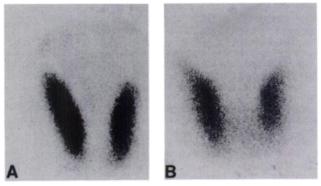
Normal thyroid gland scintigram. Little or no evidence of isthmus (123I, 300 µci, at 24 hr after tracer).
